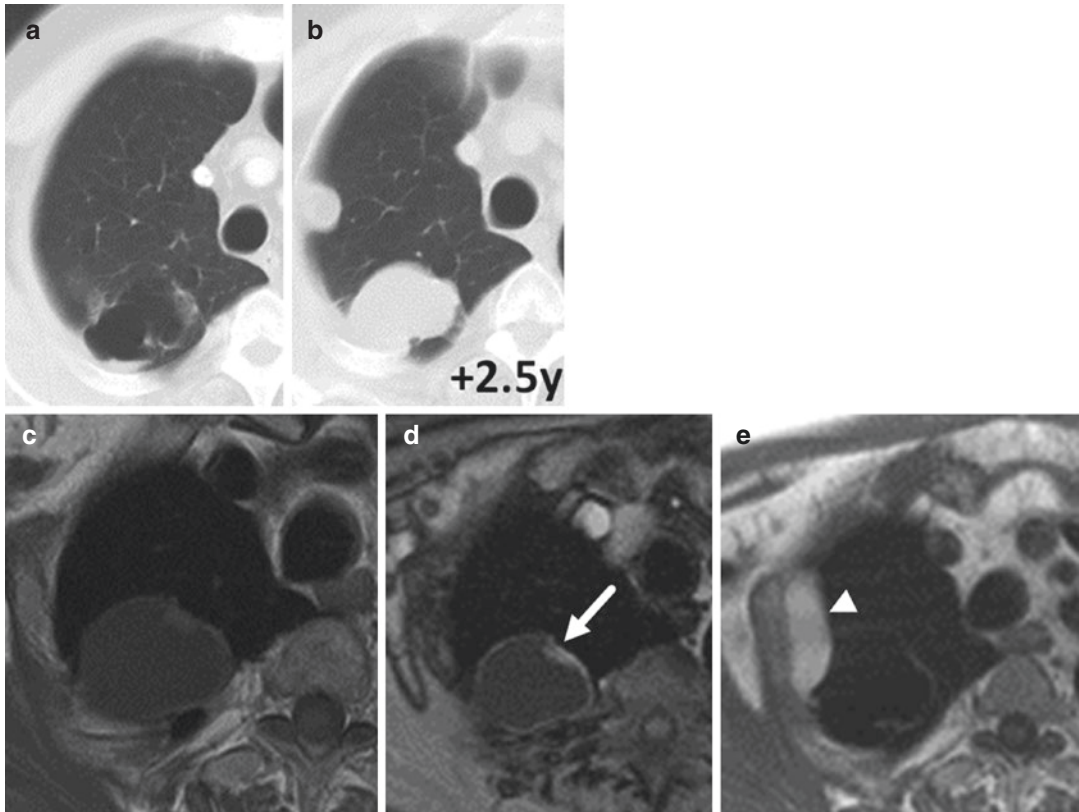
A new filling was observed within an apical cyst at CT after 2.5 years in a 65-year-old male (a, b). MRI was performed for further characterization and revealed a contrast enhancing lesion at the rim (c, d, arrow). This was verified as adenocarcinoma after surgery. MRI also
